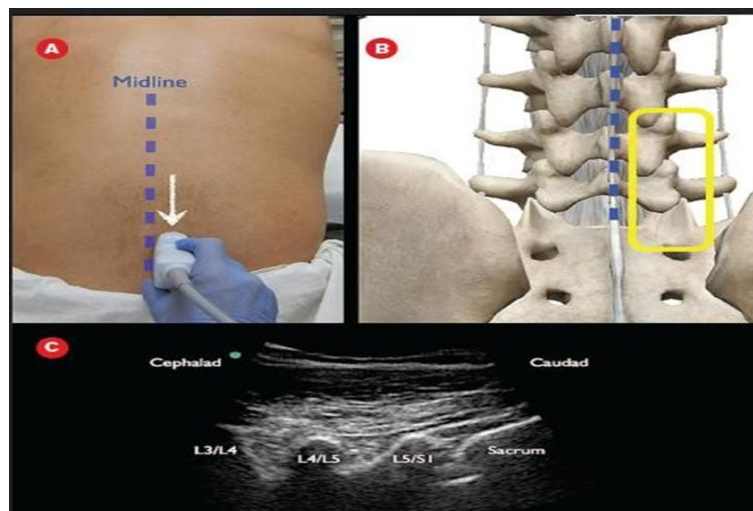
Ultrasound-Guided Localization of the L4-L5 Interspace, Variability in Tuffier's Line and Its Distance from the L4-L5 Interspace
